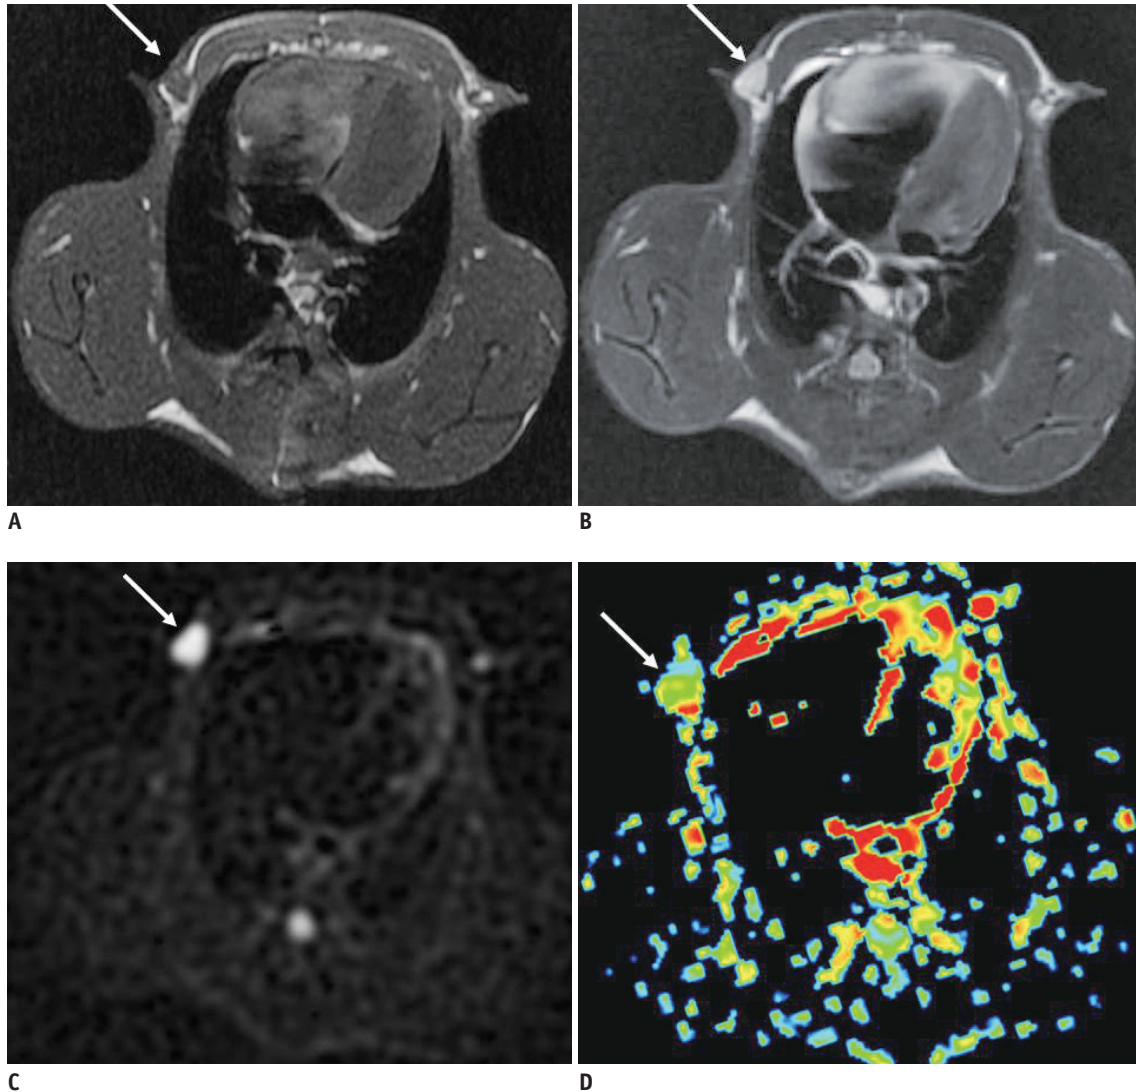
Appearance of conventional MRI, diffusion-weighted imaging and apparent diffusion coefficient map of axillary inflammatory lymph node.
